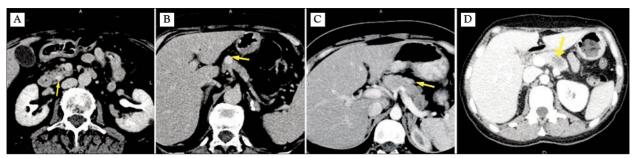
CT appearance of hypervascular (A, B – uterine leiomyosarcoma, C – retroperitoneal sarcoma) and hypovascular (D – colorectal cancer) NRPMs.
